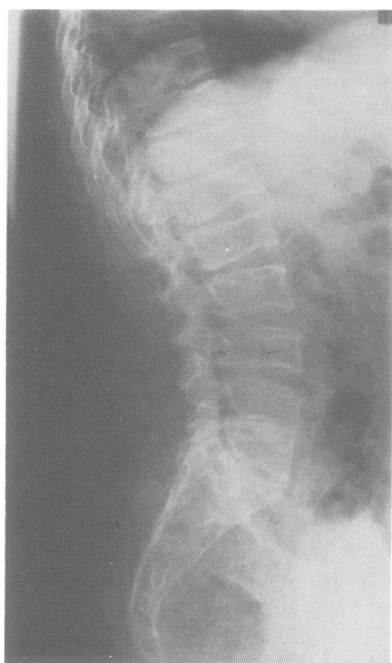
Lateral radiograph of the spine.
